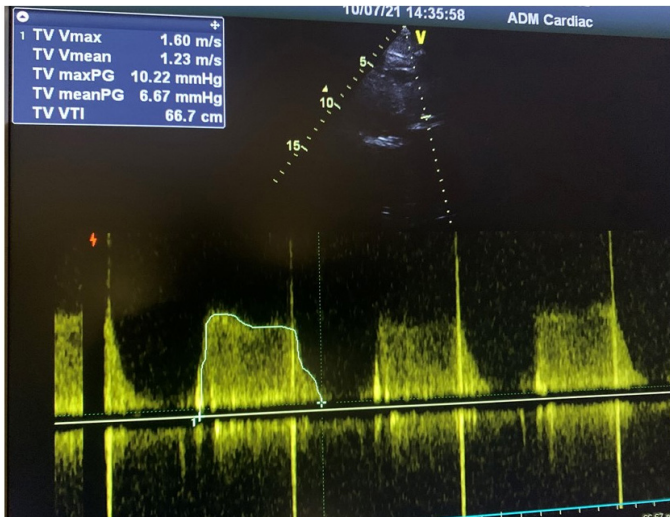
Post-procedural 45th day Doppler echocardiographic image
